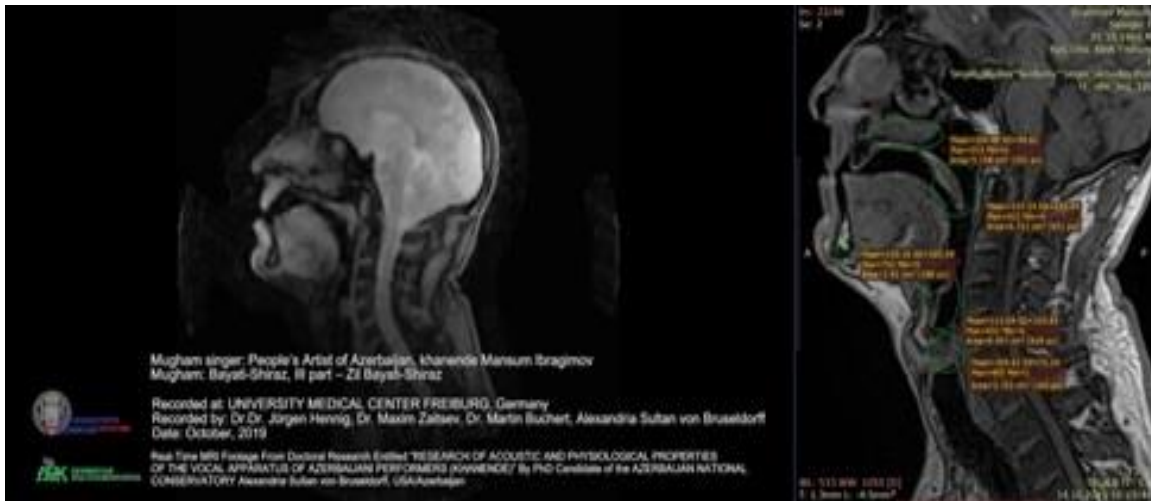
Real-time recorded MRI image of *khanende* Mansum Ibrahimov singing the *Bayaty-Shiraz mugham* produced in Germany, 2019 (left), and the process of measuring the lip opening, the width of the pharynx, and the position of the larynx using *Medixant. RadiAnt DICOM Viewer [Software] Version 2021.1.* produced in Azerbaijan, 2020 (right).
